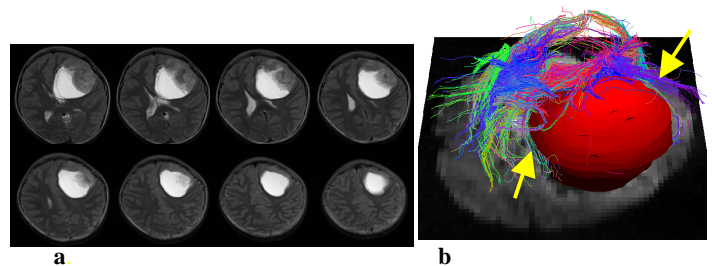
a) T2-weighted images show a tumor in left frontal lobe. b) Tractography viewing from the tumor side. The tumor (in red) displaces the callosal fibers medially. The left superior longitudinal fasciculus is stretched and displaced medially and upward by the tumor (yellow arrows).
